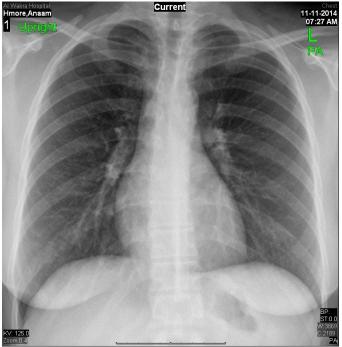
Chest radiograph in less than 4 days after initial presentation show complete resolution of the findings.
